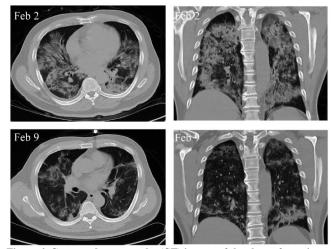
Computed tomography (CT) images of the chest of a patient with critically severe COVID-19 (adapted) (Leng *et al.*, 2020).
